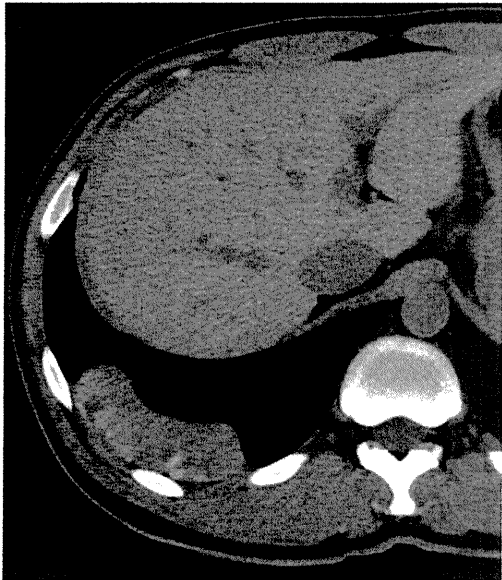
Computed tomography (CT) scan image. A subpleural mass was seen in the posterior part of the lower part of the right lung
